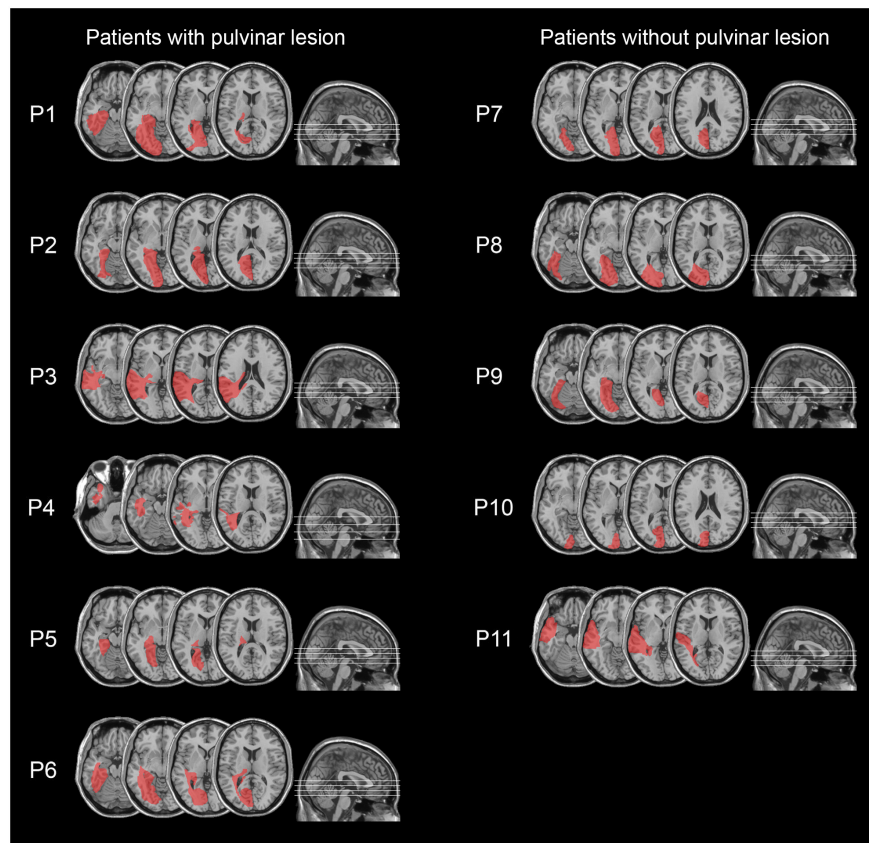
Lesion reconstruction images from CT or MRI scans, projected onto the normalized MNI template for hemianopic patients with pulvinar lesions (P1–P6; left column) and hemianopic patients without pulvinar lesions (P7–P11; right column).
